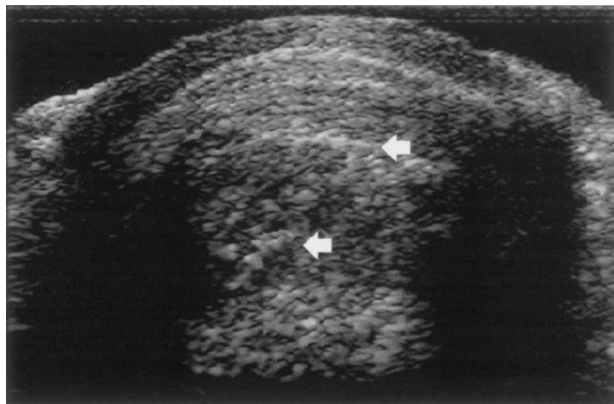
Ultrasound image of an intervertebral disc. Arrows indicate the positions of increased echo levels.
